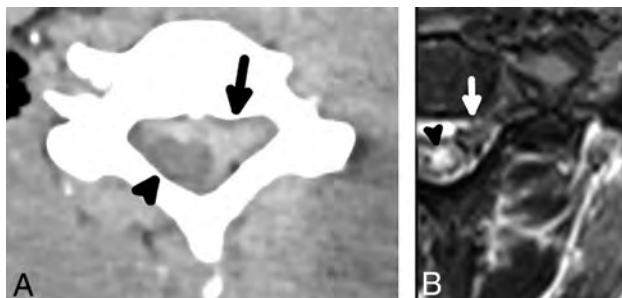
A 42-year-old man with preganglionic BPI and extra-axial hemorrhage. An axial CT image (A) shows a large extra-axial hematoma centered at the left of the spinal canal (arrow), which appears to compress the eccentric spinal cord (arrowhead). An axial T2 STIR MR imaging (B) in the same patient performed a day later shows an extra-axial hematoma (arrow); the hematoma and motion artifacts on the examination limit the diagnostic quality, but multilevel nerve rootlet avulsions are evident on sequential images. There is also severely abnormal signal hyperintensity (arrowhead) and a probable focus of hemorrhage (focal T2 hypointensity) in the spinal cord.
